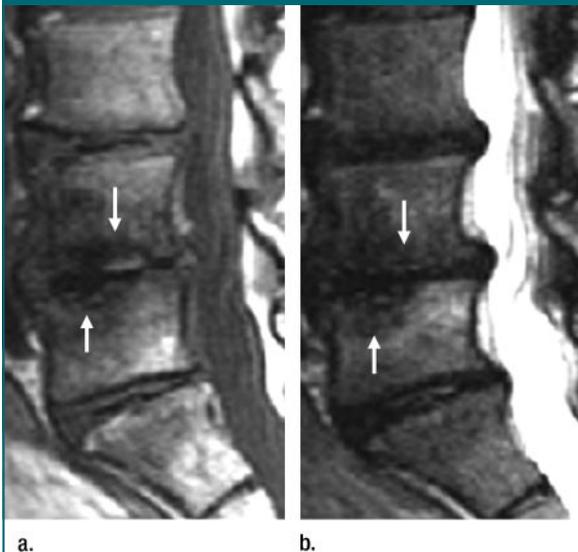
Degenerative type III vertebral body marrow changes. Sagittal midline (a) T1-weighted (450/12) and (b) fast SE T2-weighted (4000/120) images demonstrate markedly decreased signal intensity of adjacent marrow spaces at L4-5 in the presence of severe degenerative disk disease (arrows).
